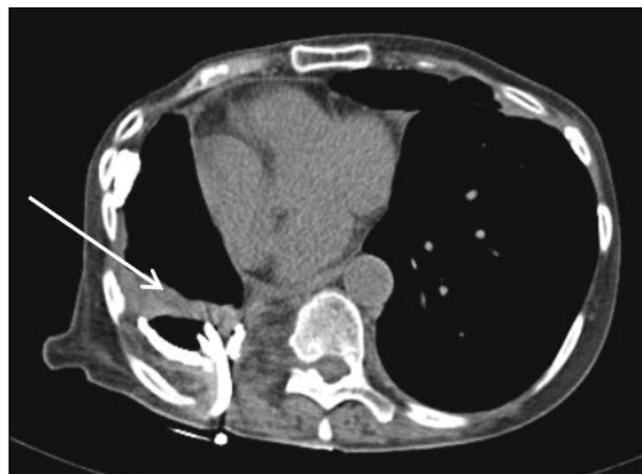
CT total body: abscess in the posterior right side of the pleural space with the insertion of the drainage tube (arrow).
